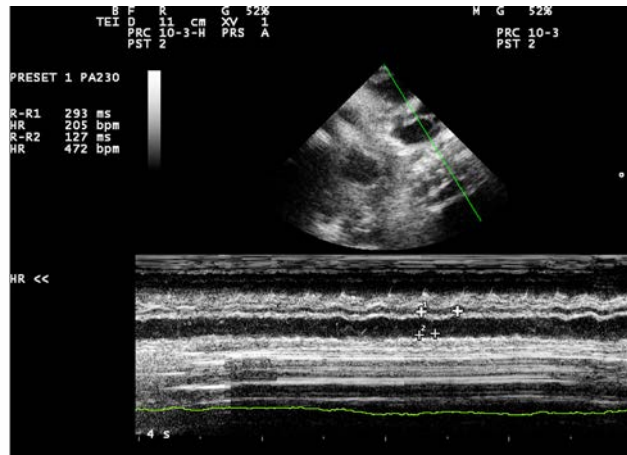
Doppler imaging (M-mode) of a newborn P (girl), third day of life.
